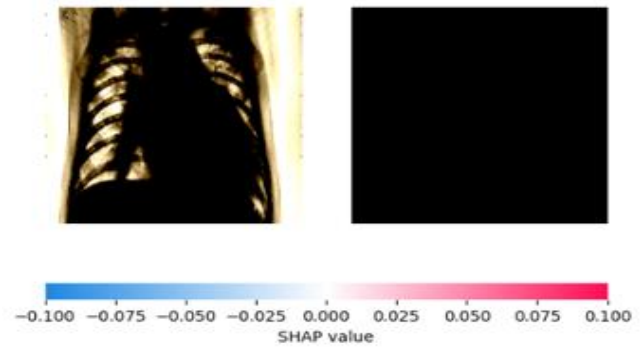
SHAP features value of a Bacterial X-ray image for Nyangena Hospital
